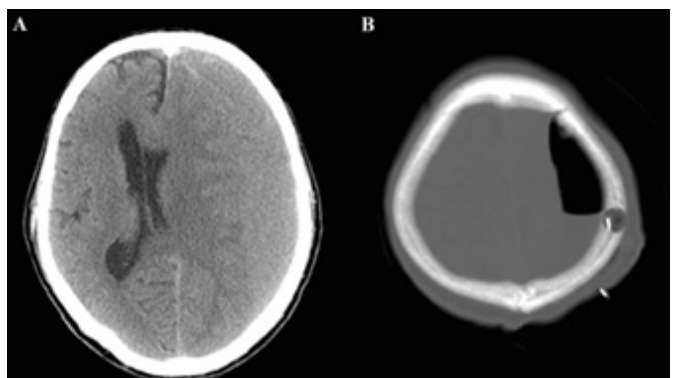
A: Chronic subdural hematoma preoperative CT scan, B: Postoperative CT scan burr hole craniostomy
